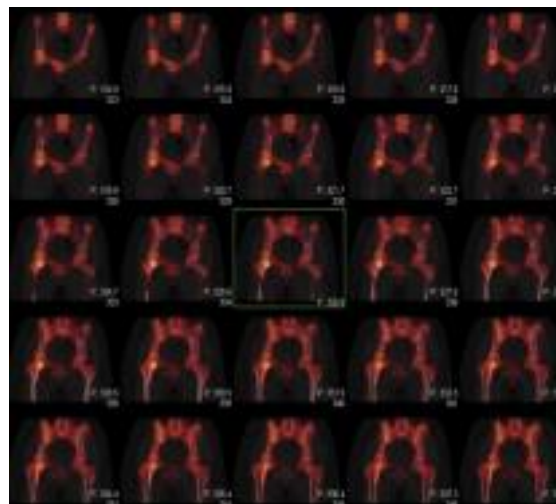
SPECT/CT confirm uptake at the site of a nidus of the osteoid osteoma.
